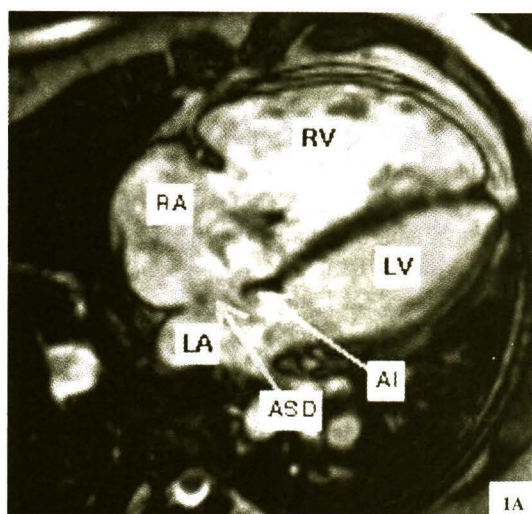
Cardiac MRI of an ASD showing a four chamber view.
